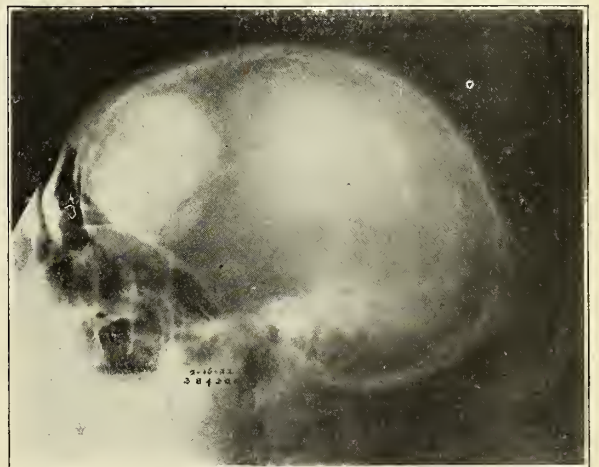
(Case A384300). Lateral roentgenogram showing an endotheliopsammoma of the frontal bone.
